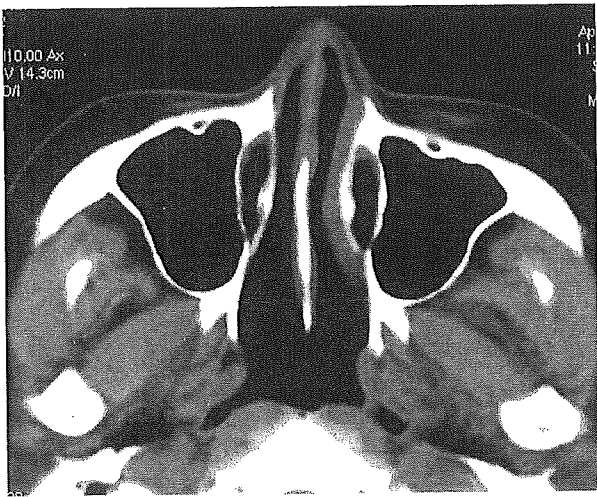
Computed tomography taken after treatment (chemo-radiotherapy) of Case 1. The tumor disappeared from the patient's nasal and paranasal cavities.
